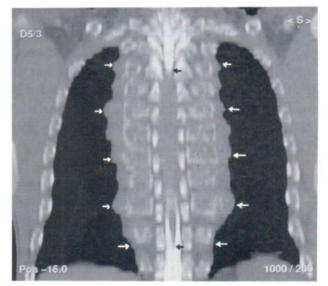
Curve coronal reconstruction of CT intraspinal myelography shows both lobulated paravertebral masses and intraspinal extradural lesion.
